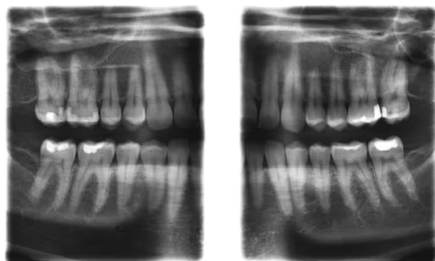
Extraoral Bitewings
